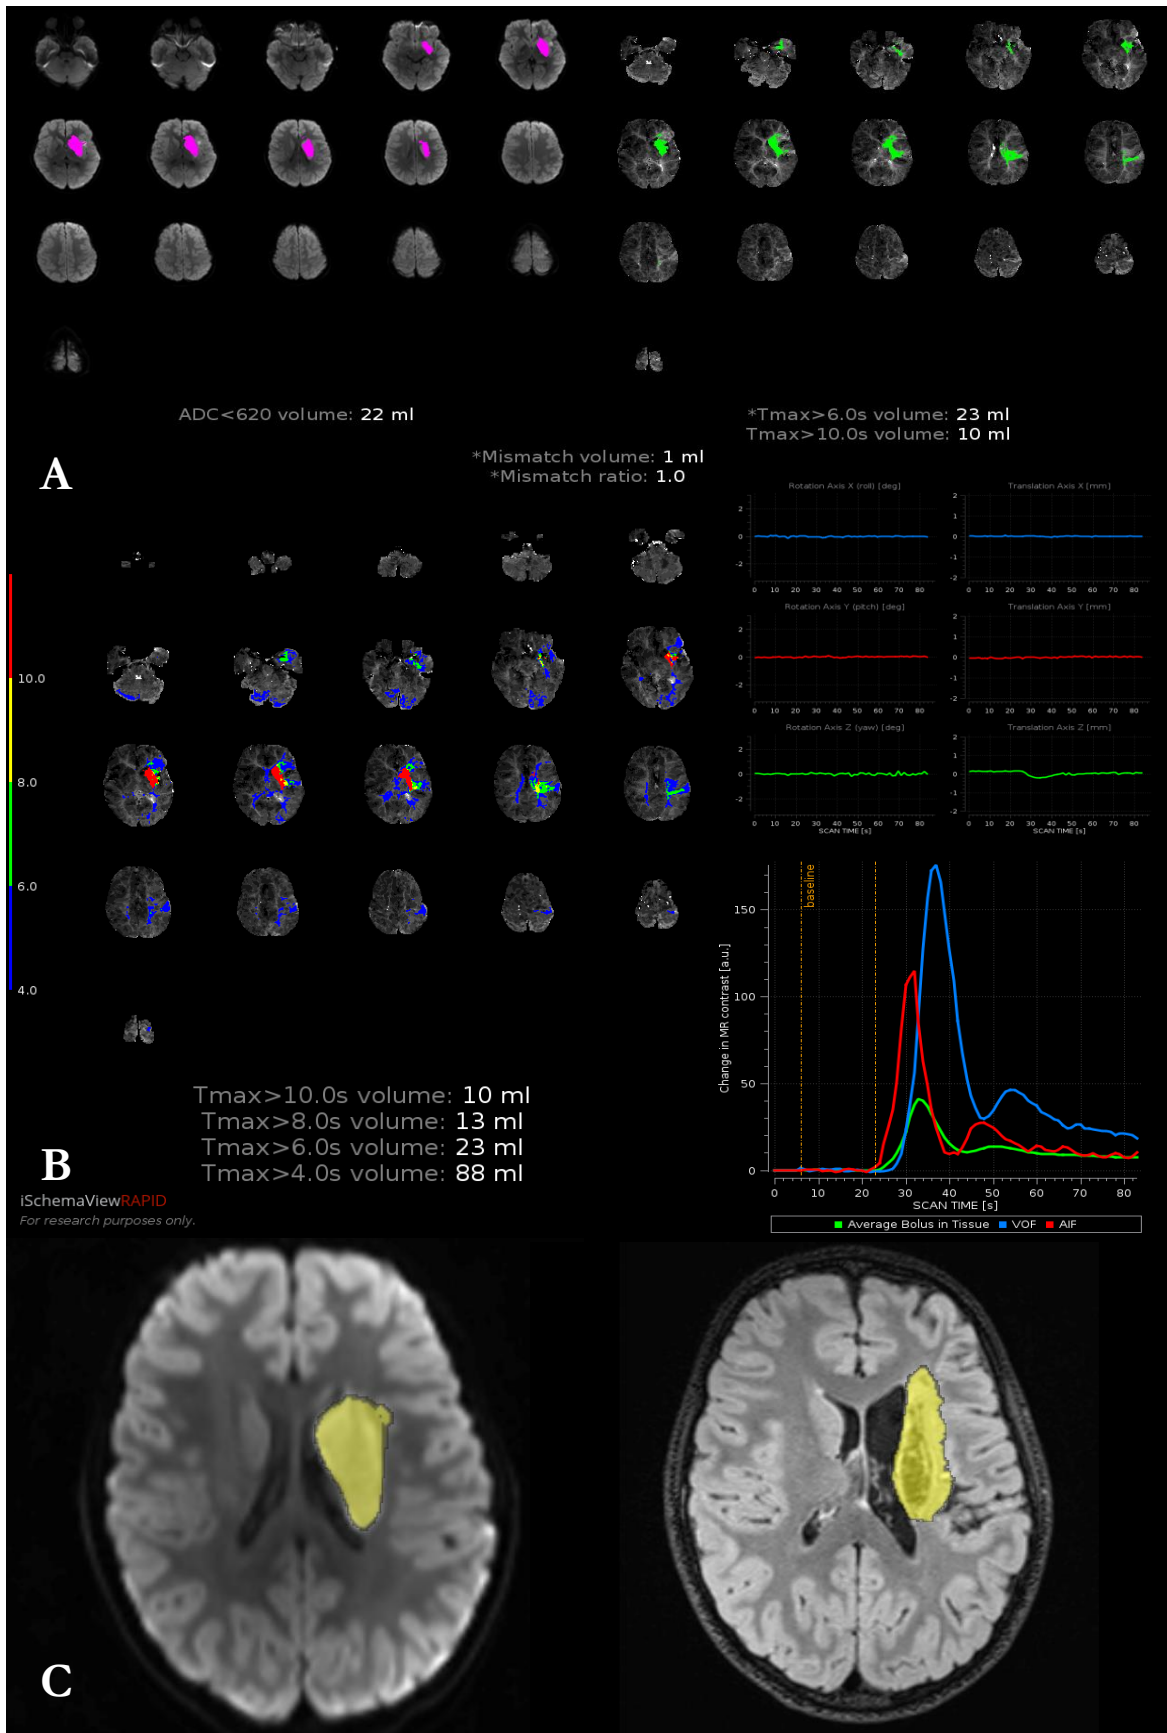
RAPID output and manual segmentation Case study 5 (A) Automated mismatch segmentation core (left) hypoperfusion (right) using standard RAPID thresholds (B) Alternate  $T_{max}$  thresholds, head motion, and AIF curves. (C) Manual segmentation of acute DWI lesion 18.2mls (left) and chronic T2 FLAIR lesion 19.9mls (right)
